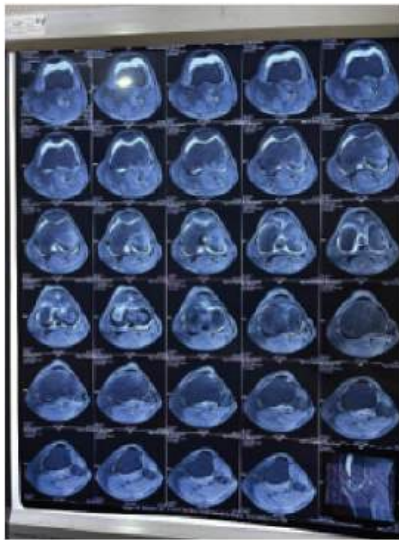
Axial MRI of right knee joint
